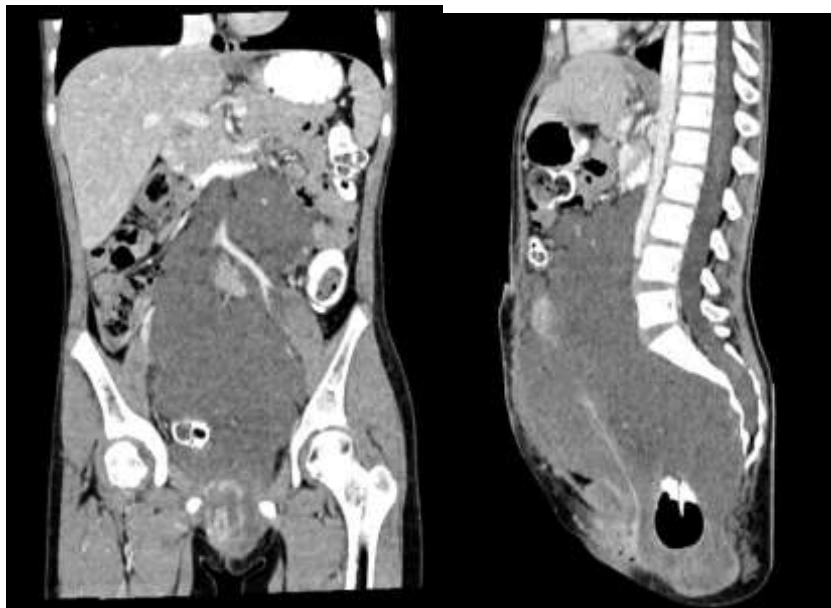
CT Scan examination obtained A picture of a heterogeneous solid mass with a low density in the pelvic cavity extending to the abdominal cavity
